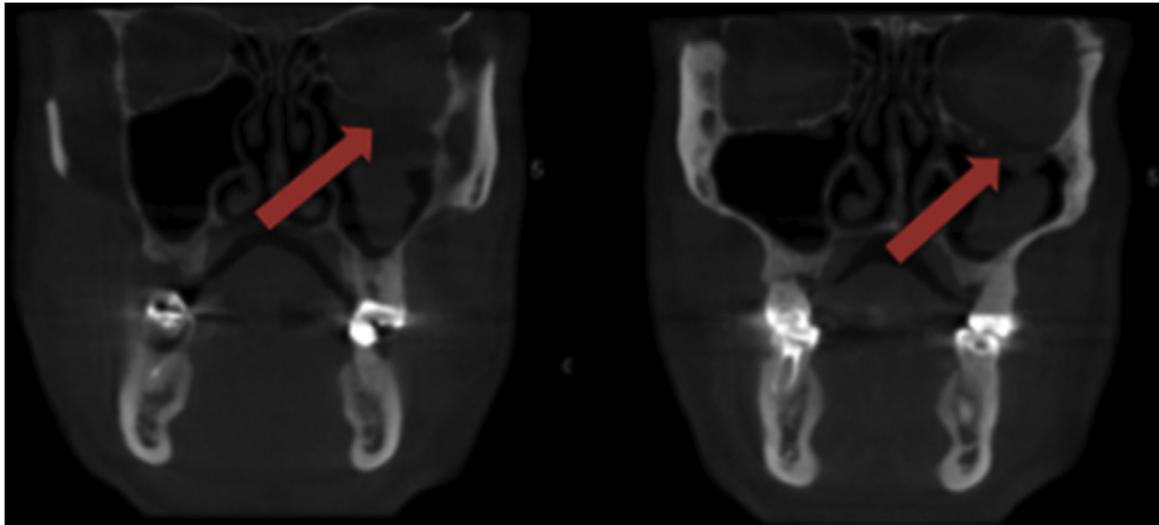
Cone beam computed tomographic scan of the patient in Fig. 3 showing the orbital floor defect (red arrows) resulting from the removal of orbital floor in surgery to relieve retrobulbar haematoma. (CS 9300, Carestream, Rochester, NY).
